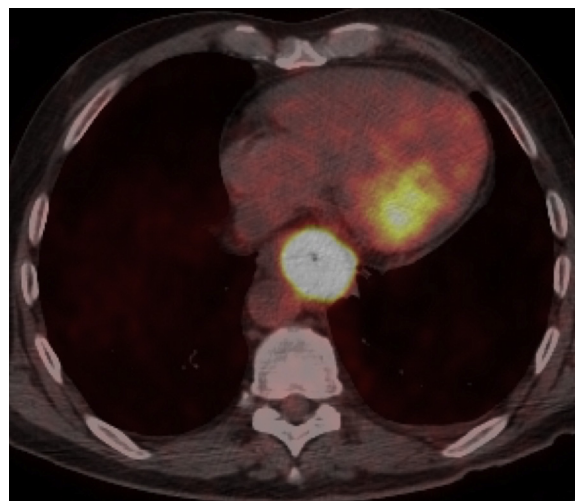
Axial fused PET/CT image of a distal oesophageal adenocarcinoma which had a positive CRM following surgical resection.
